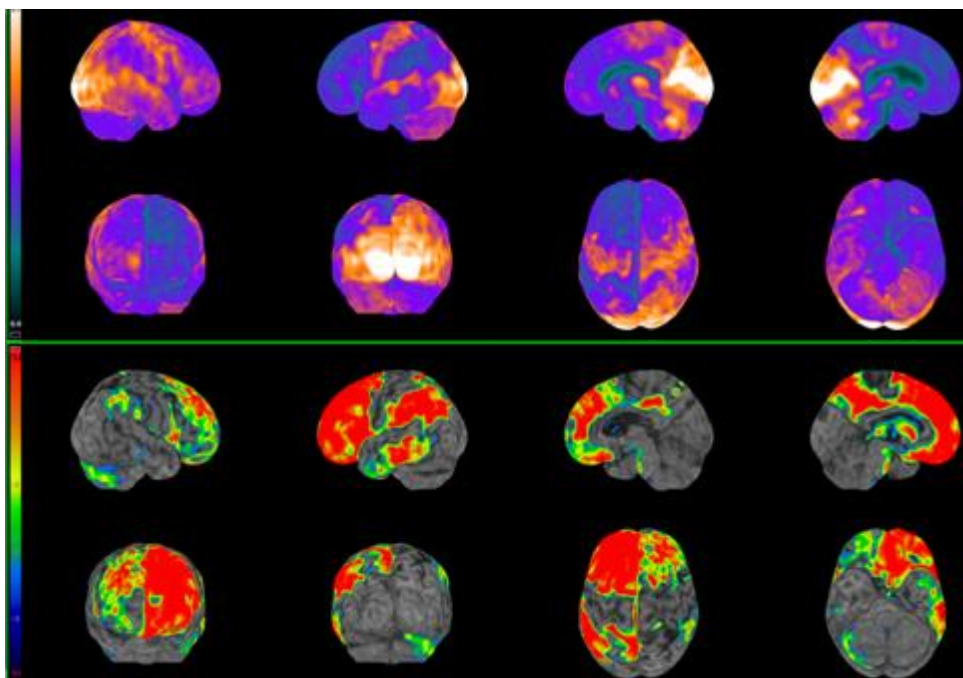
FDG-PET disclosing FTD hypometabolic pattern
